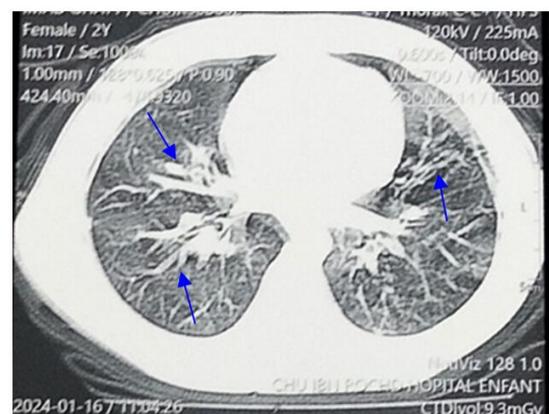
Thoracic CT scan showing retractile moniliform bronchiectasis of the middle lobe and left posterobasal lobes, associated with peribronchial thickening, with left posterobasal branching micronodules, pre-aortic calcified nodes, lingular and middle lobar band atelectasis.
